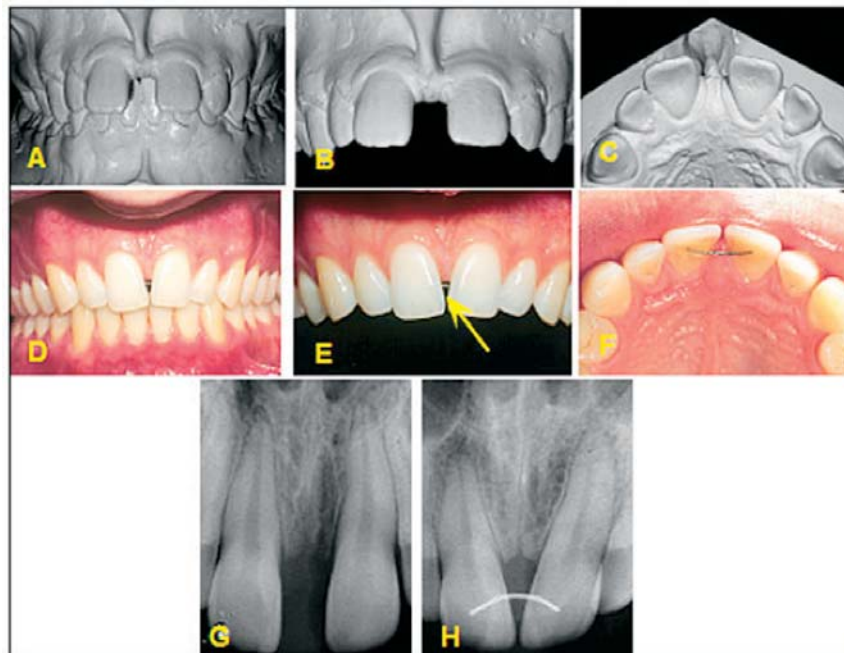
A-C. Large pre-treatment diastema. D-F. Space closure with no attention paid to root parallelism and the resultant “black triangle” (arrow). G and H show on the periapical radiographs the lack of roots parallelism.
